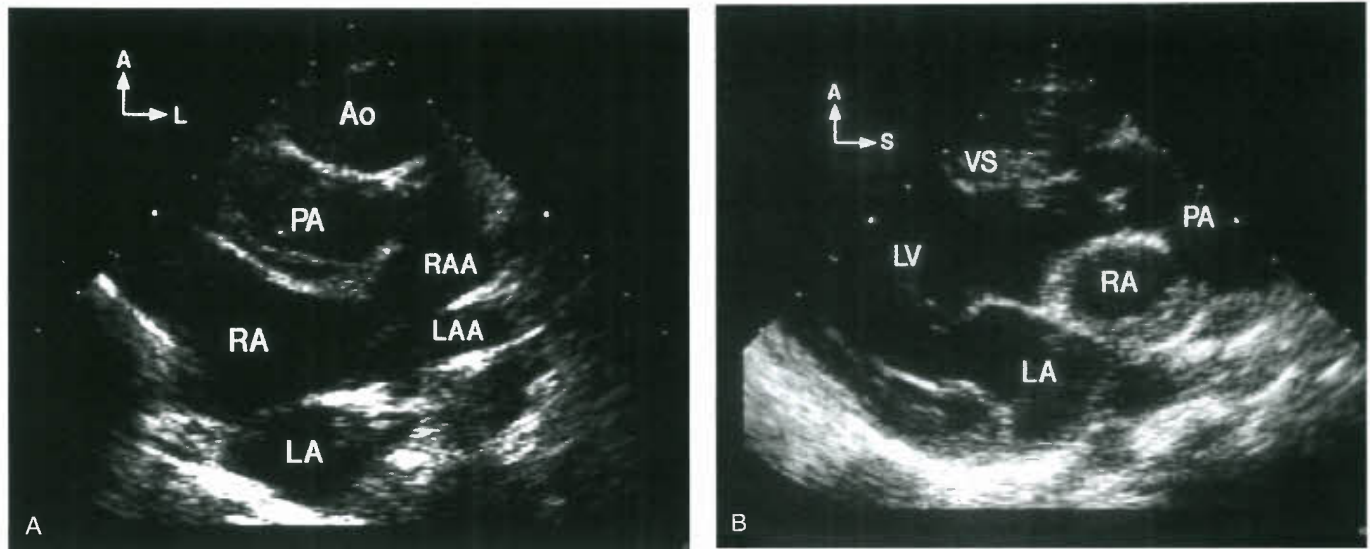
Left-juxtaposed atrial appendages in double-outlet right ventricle (RV). A: High left parasternal short-axis scan demonstrating left-juxtaposed atrial appendages in a patient with double-outlet right ventricle. Note the wide base and more bulbous appearance of the right atrial appendage (RAA) located more anteriorly and superiorly. The left atrial appendage (LAA) has a narrow base and finger-like projection. B: Parasternal long-axis scan of the same patient demonstrating the pulmonary artery (PA) coursing posteriorly and primarily originating from the anterior RV. Because the right atrium (RA) courses behind the PA in left-juxtaposed atrial appendages, it also separates the pulmonary artery from the mitral valve. A, anterior; Ao, aorta; L, left; LA, left atrium; S, superior; VS, ventricular septum.
